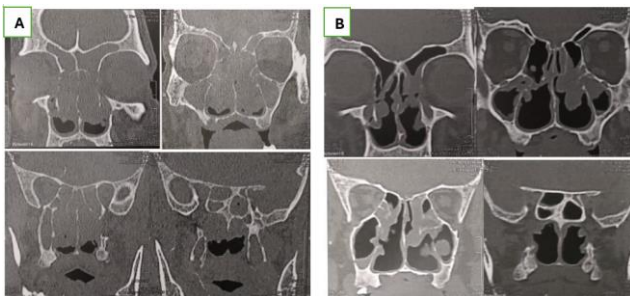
A: CT scan for a case with Lund Mackay score 24 before administration of dupilumab. B: CT scan for the same case with Lund Mackay score 8 after 6 months of administration of dupilumab
